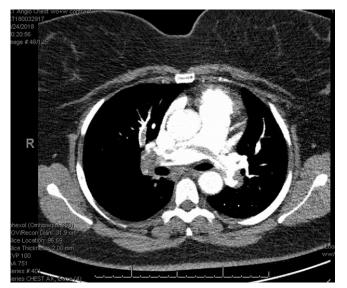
CTA Transverse plane showing saddle pulmonary embolism and thrombus in both pulmonary arteries.
